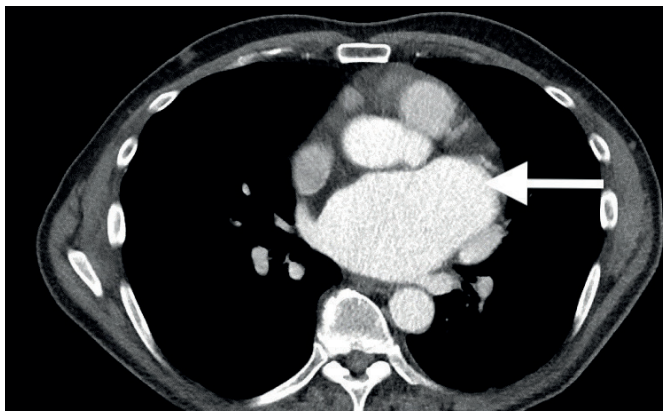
CT Chest reveals dilated coronary sinus
